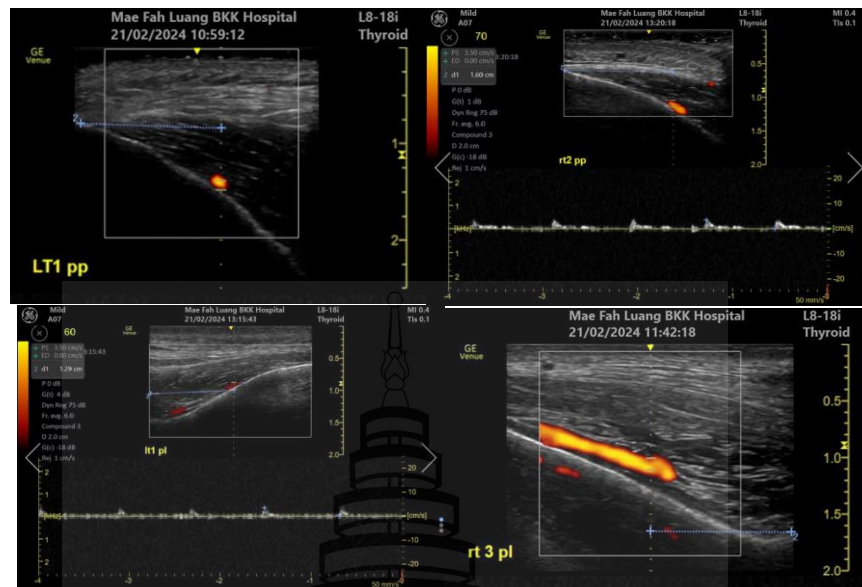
Photos of subject showing deep temporal arteries during temporal ultrasound detections that are parallel and perpendicular to the temporal crest at Points T1, T2 and T3 (T1PP, T2PP, T1PL & T3PL)
